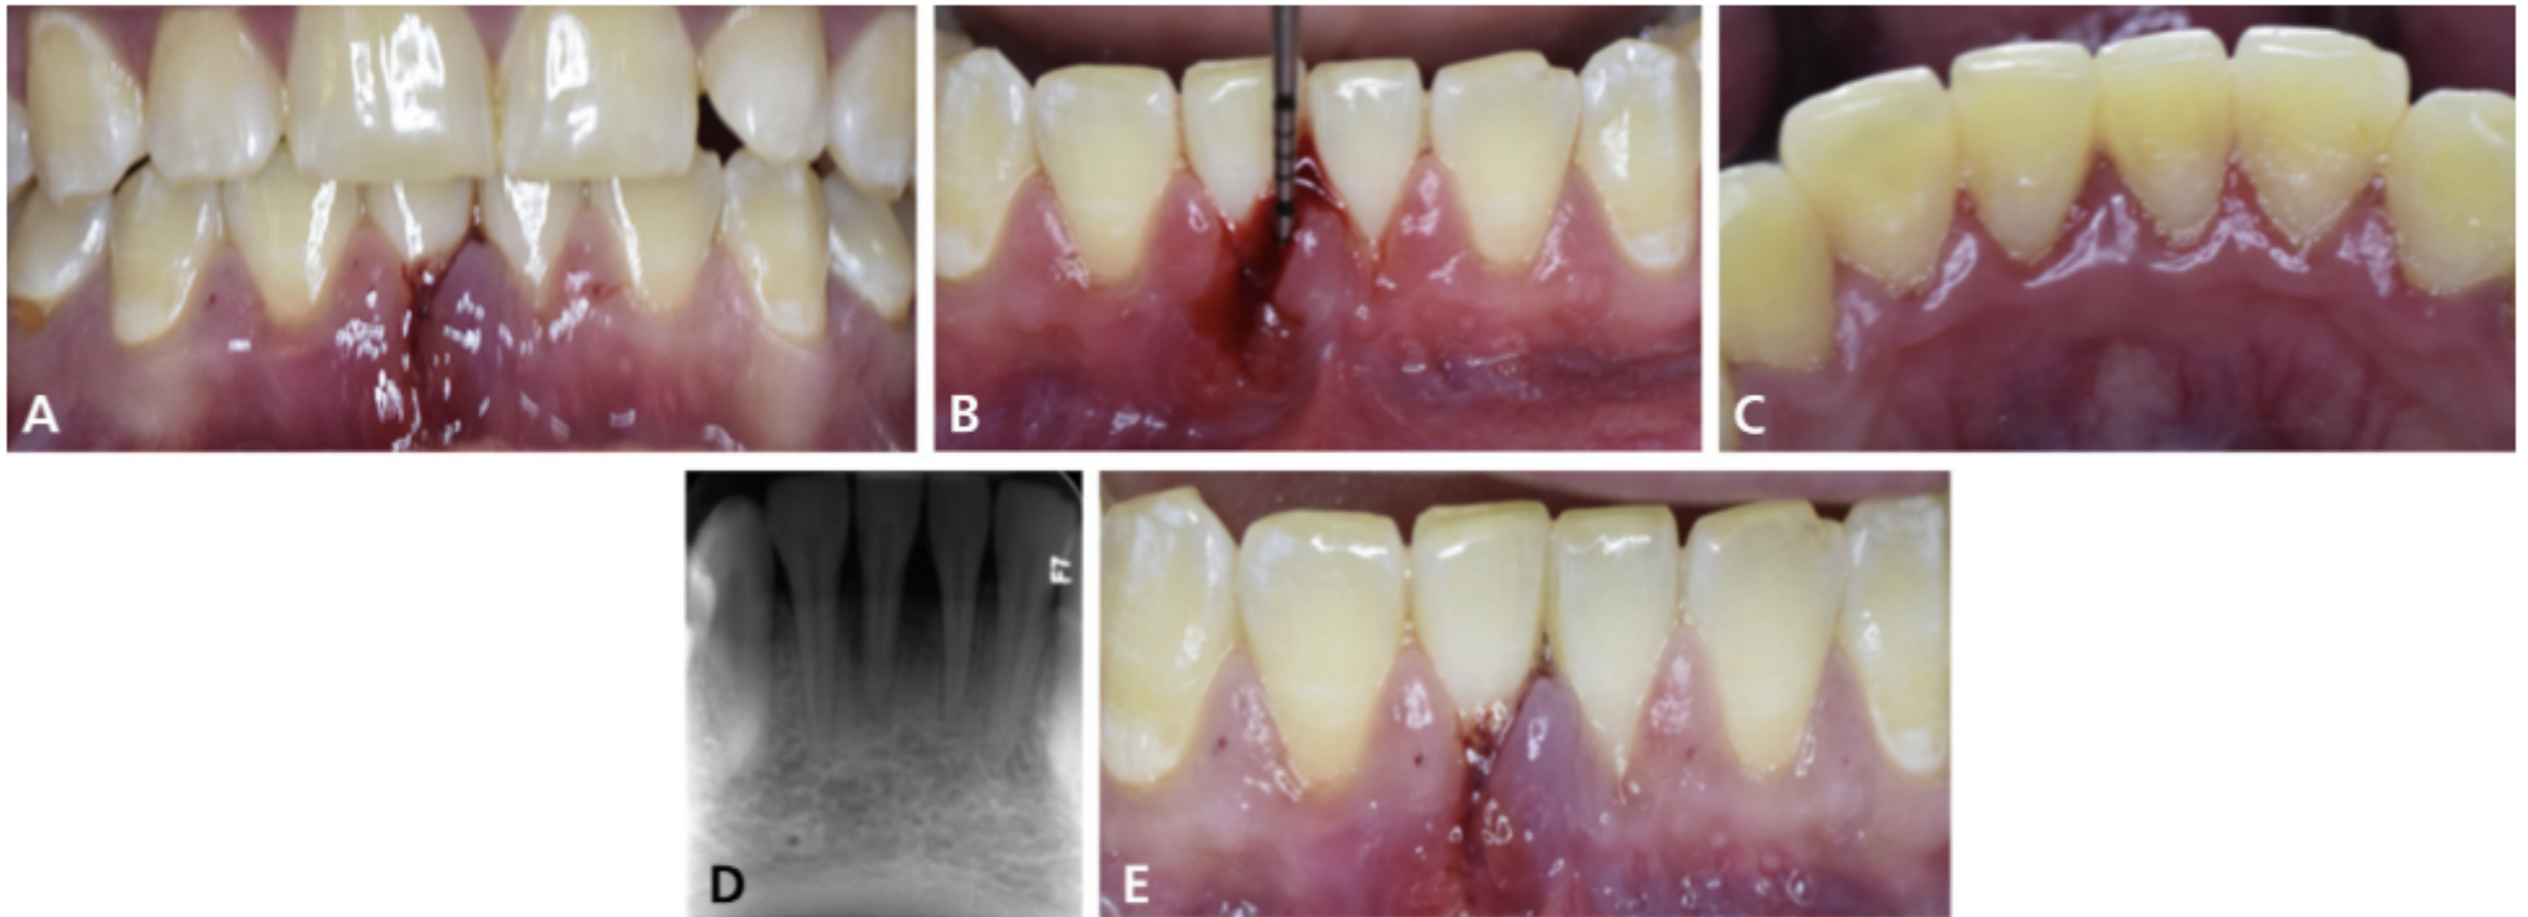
Clinical and radiographic presentations during initial visit and nonsurgical therapy. A. Initial visit, frontal view. B. Initial visit, facial view of mandibular anterior teeth showing papillary gingival enlargement and edematous tissue with increased probing depth (7 millimeters) at the mesiofacial aspect of teeth nos. 24 and 25. C. Initial visit, lingual view of anterior teeth showing nodular appearance. D. Radiographic bone loss seen at the mandibular anterior teeth (nos. 23-26) with more prominent bone loss at interproximal site of teeth nos. 24 and 25. E. Frontal view at re-evaluation visit 4 weeks after scaling and root planing.
